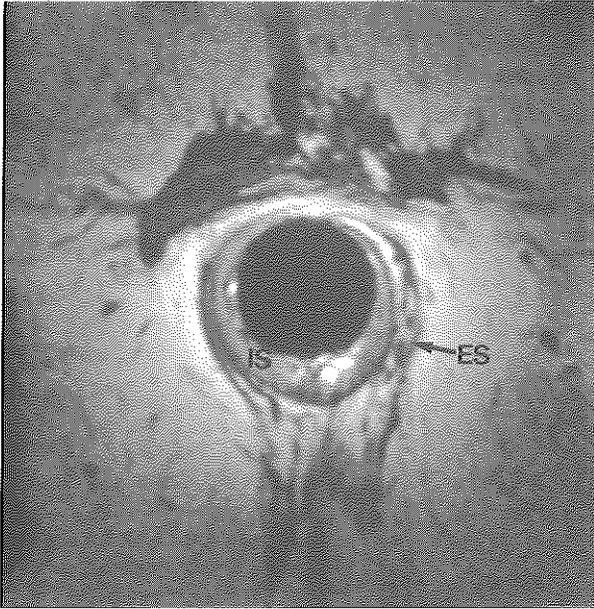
Endoanal MRI, axial proton density GRE showing severe atrophy of the external sphincter (ES). (Compare with Figure 1). Internal sphincter (IS).
